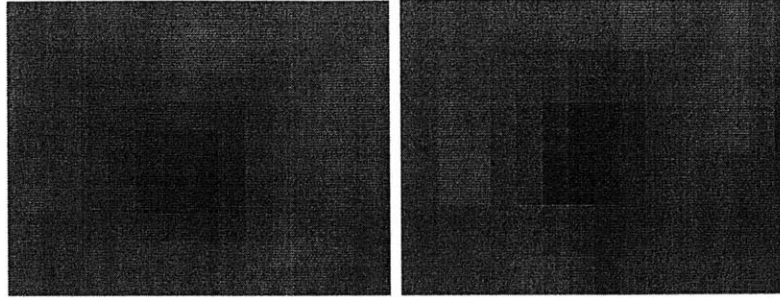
An axial (left) and sagittal (right) closeup view of an MR seed, which has been reformatted into CT space using 3PR registration. The sagittal view has been stretched in the vertical axis according to the slice:pixel ratio to form an isometric view. Each pixel width (and half the vertical pixel height in the sagittal view) corresponds to 0.625 mm.
